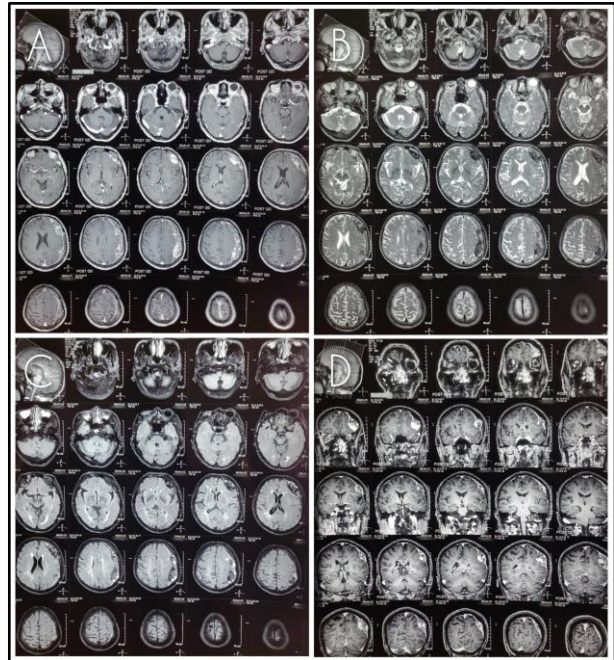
A: MRI Axial T1 weighted image with contrast, B: MRI Axial T2 weighted image, C: MRI FLAIR image, D: MRI Coronal T1 weighted image with contrast showing left sided frontoparietal calcified chronic subdural hematoma
